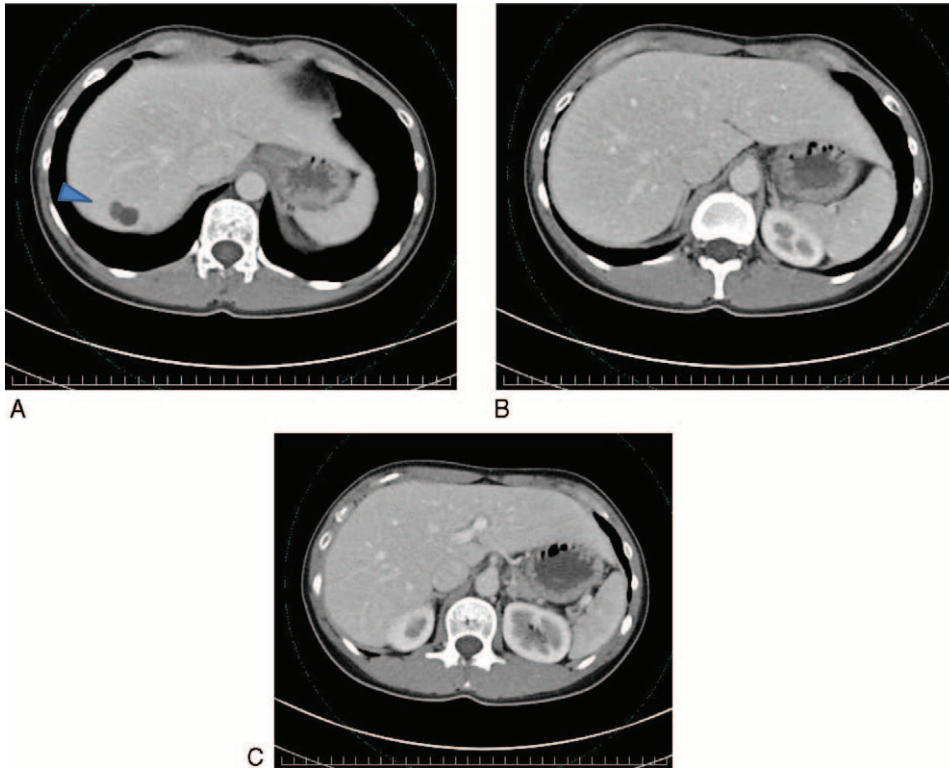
Contrast-enhanced computed tomography images from after the completion of bevacizumab/paclitaxel/carboplatin therapy in 2014. Metastatic lesions were replaced by visible cavitations in S7 (arrows indicate cavitations; (A), which subsequently disappeared (B and C).
